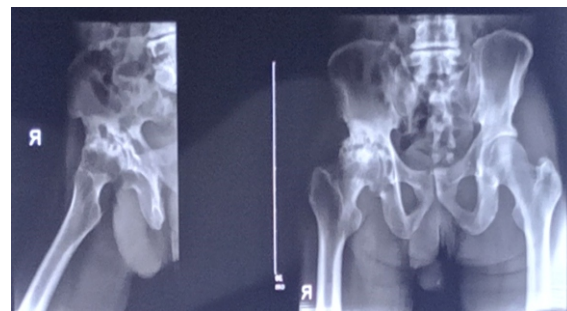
Pre-operative anterior-posterior x-ray film of the pelvis and lateral x-ray film of the right hip
